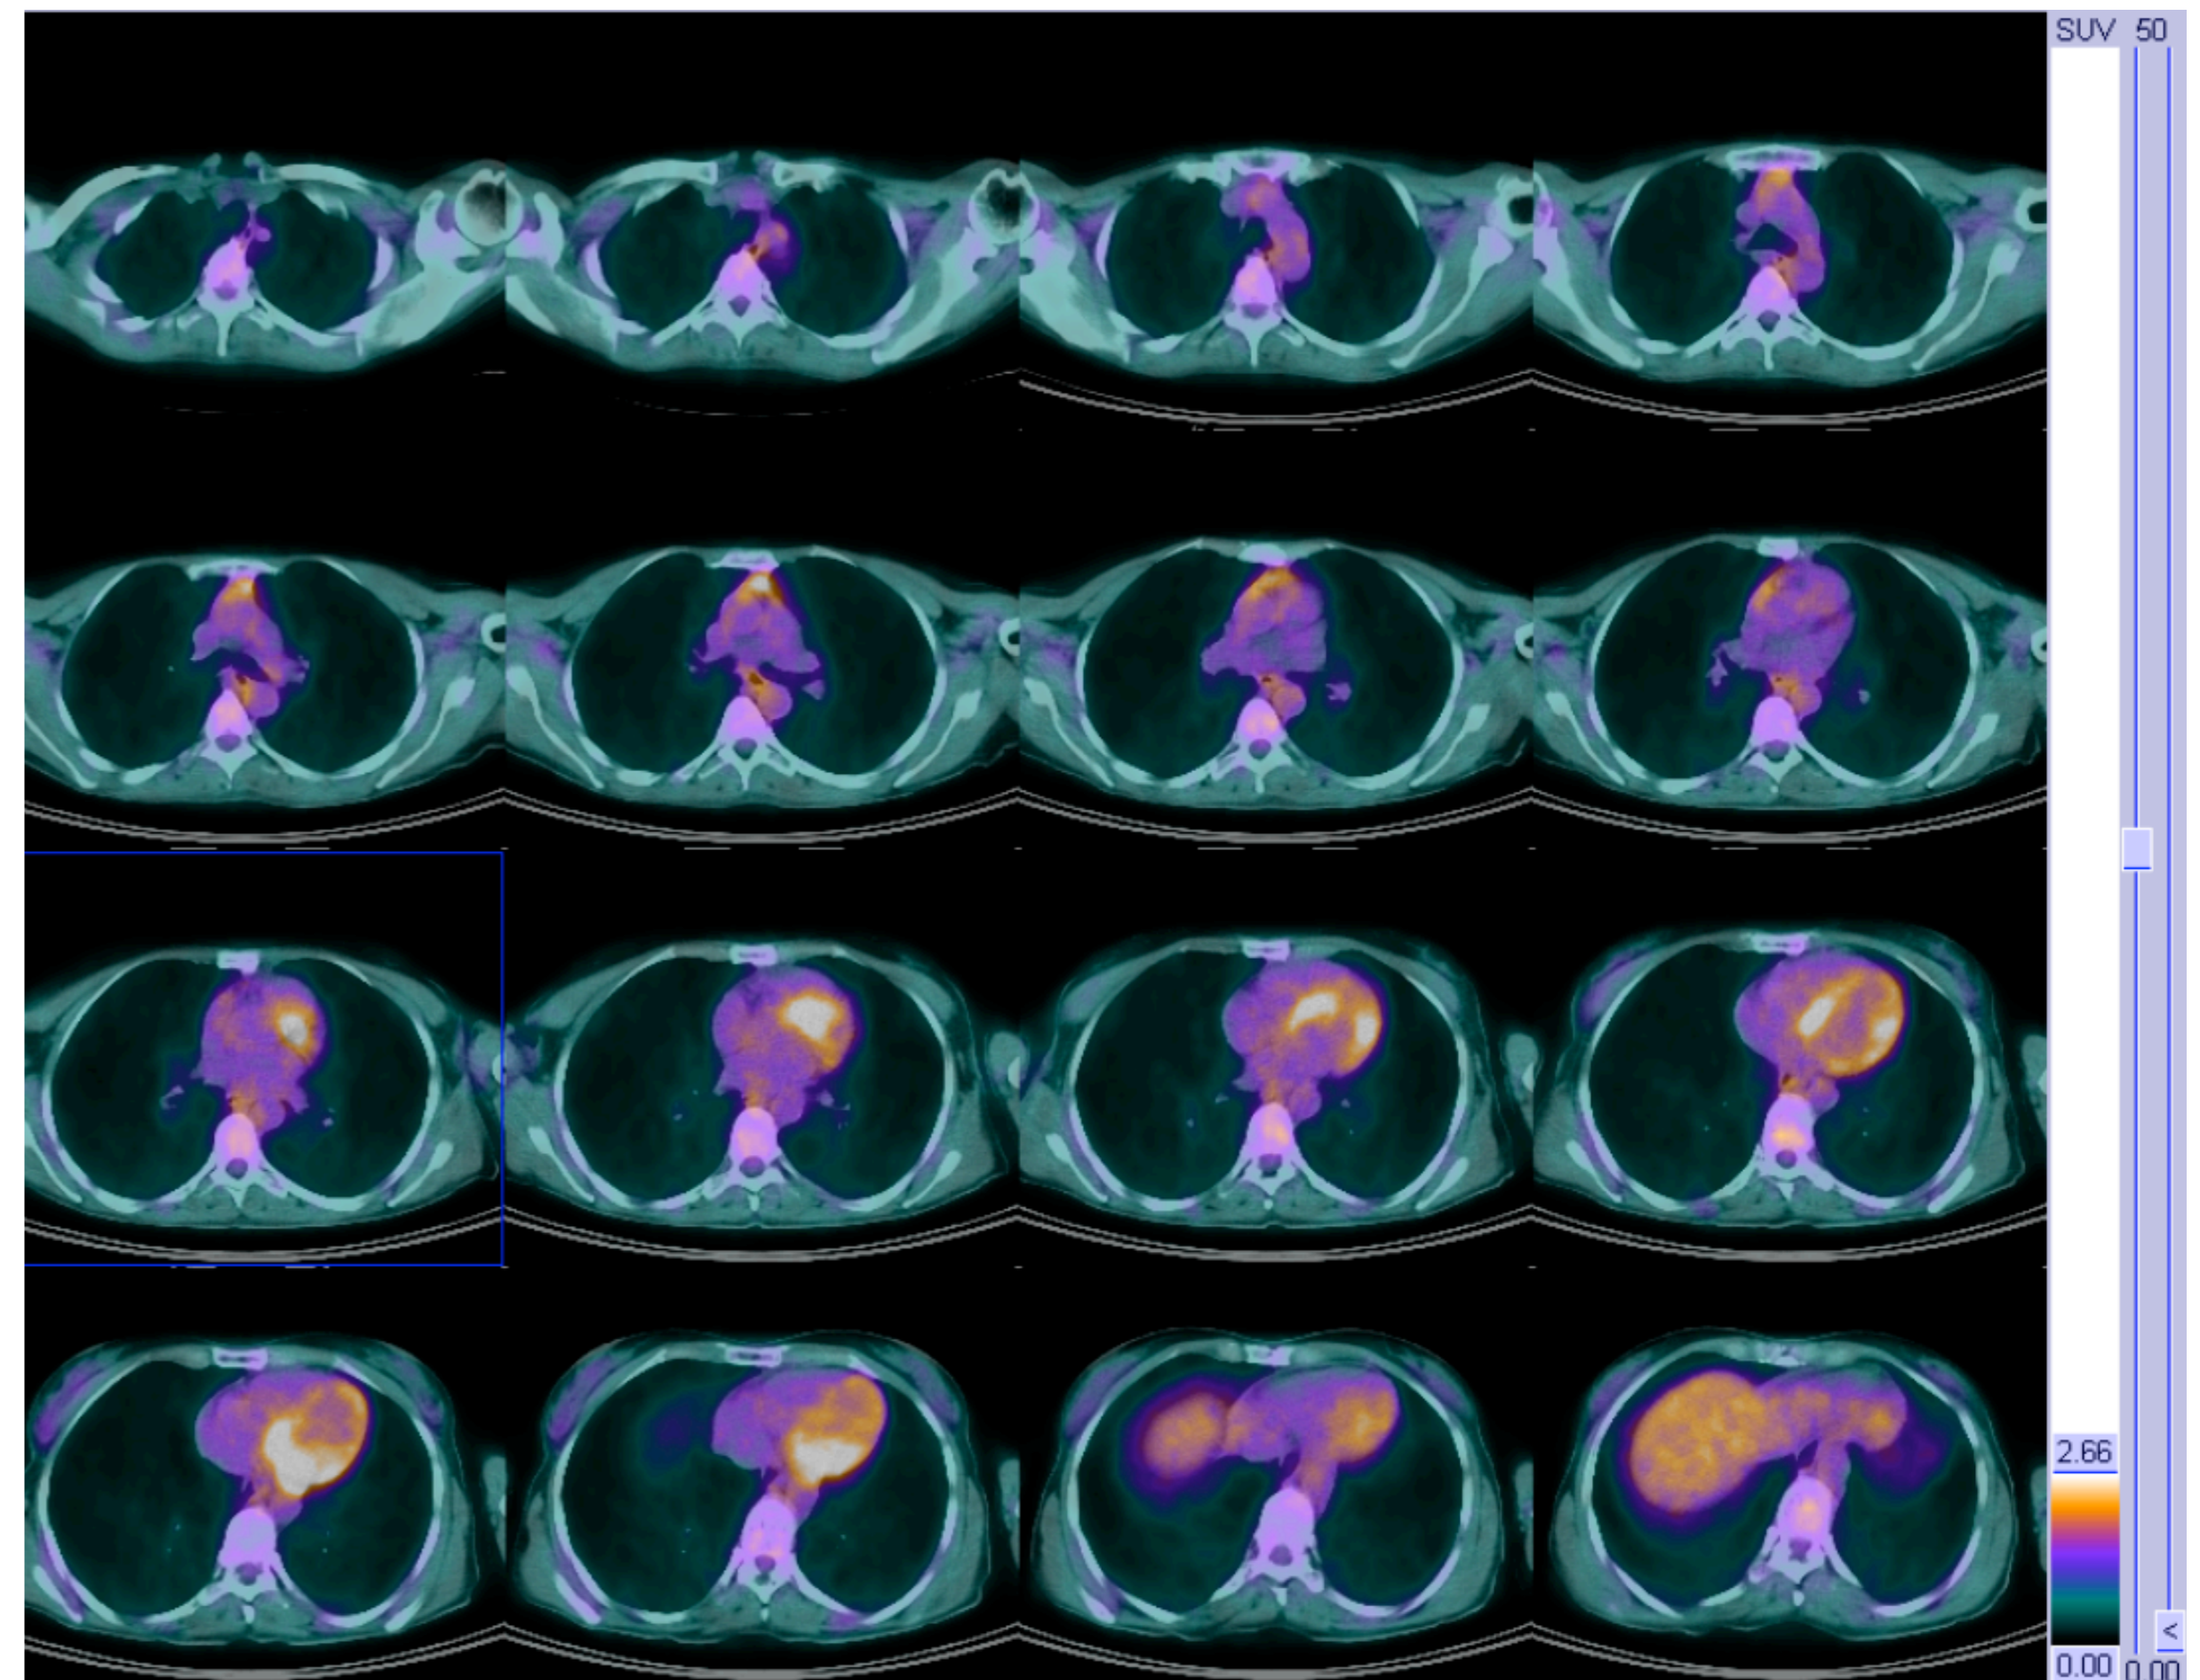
¹⁸F-fluorodeoxyglucose-positron-emission tomography (¹⁸F-FDG-PET) scans of the chest: increased glucose-uptake in the thymus area (SUV max 3.3) corresponding to a metabolically active enlarged residual thymus gland.
